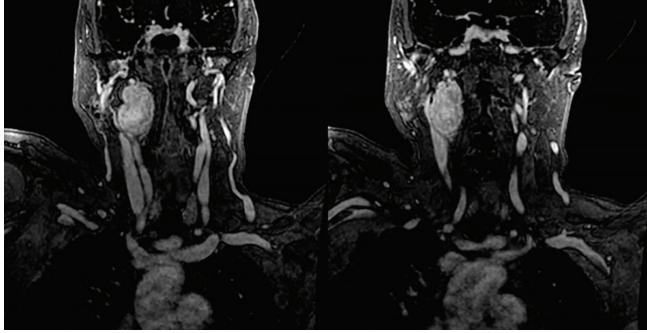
Coronal MRI T1-W sections demonstrated glomus tumor at the level of vagal nerve with high signal of the lesion with clear borders and no adjacent tissue involvement
